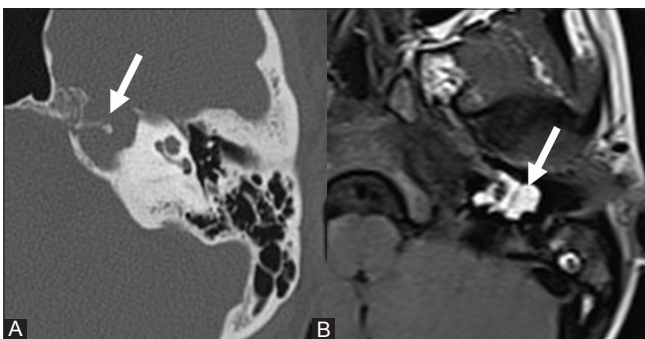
(A, B): Axial CT and MRI-T1 weighted image shows soft tissue expansile lesion in the petrous apex, the soft tissue being hyperintense on T1W MRI – cholesterol granuloma
